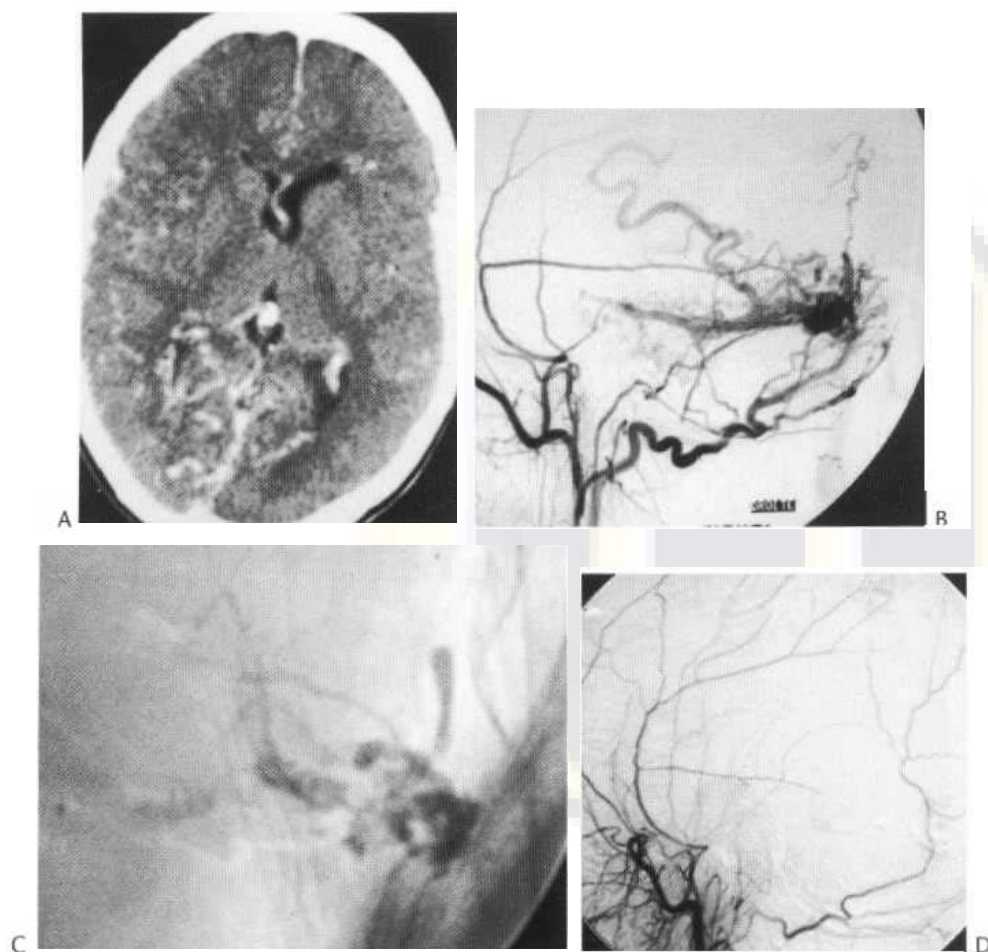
Embolisation of dural arteriovenous shunt causing cortical venous congestion. CT with contrast (A) demonstrating dilated cortical and deep veins, including the septal vein. Right ECA angiogram (B) demonstrating a dural fistula of right transverse sinus supplied by meningeal and transosseous branches with retrograde cortical venous reflux. Unsubtracted image (C) showing NBCA glue cast at the site of the fistula. Note how the glue has penetrated the venous side of the fistula, with the cast corresponding to the zone of shunting demonstrated in (B). Right ECA angiogram (D) demonstrating complete occlusion of the fistula. Note the decrease in calibre of the occipital artery on this follow-up angiogram. (Courtesy of Prof. P. Lasjaunias.)
